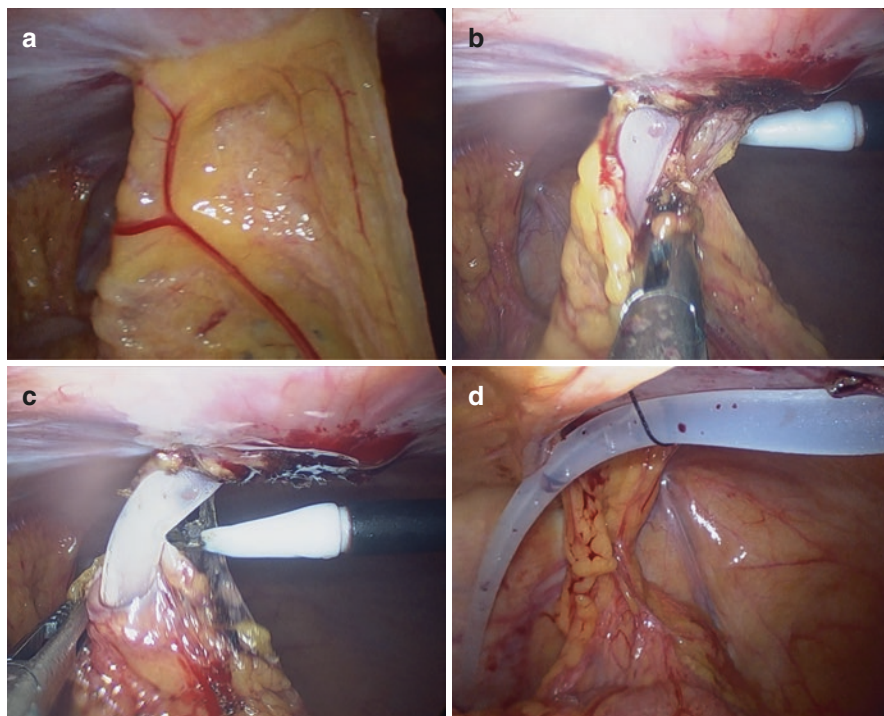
A 46-year-old male patient with a history of appendectomy received peritoneal dialysis catheter insertion using open surgical technique. The procedure was difficult, and intra-abdominal adhesion was speculated. However, it succeeded and the catheter flush was satisfying. Despite an abdominal plain film showing catheter tip right in the pelvic cavity on the first postoperative day, two-way obstruction was observed 1 week after insertion. Conservative treatments were not rewarding, and laparoscopic manipulation was performed 20 days after insertion. Laparoscopy showed that the intra-abdominal portion of the catheter was completely encased by omentum, and the omentum adhered to the parietal peritoneum at the site of catheter entry (Panel A). Omental adhesion was observed at the other part of peritoneal cavity as well. Adhesiolysis (Panels B and C) and catheter tip fixation (Panel D) were performed. Peritoneal dialysis treatment has been uneventful afterward
